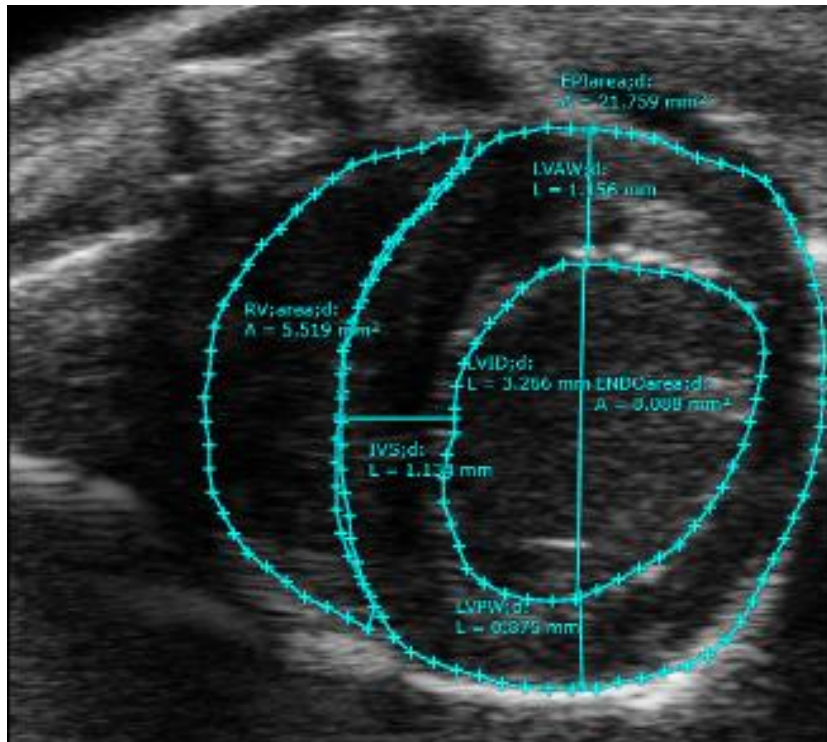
2D of Parasternal short-axis view, at the papillary muscle level.
